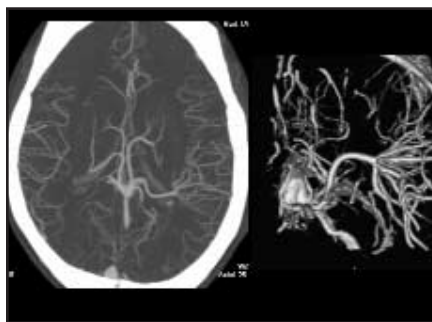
CTA of left frontoparietal developmental venous anomaly.
